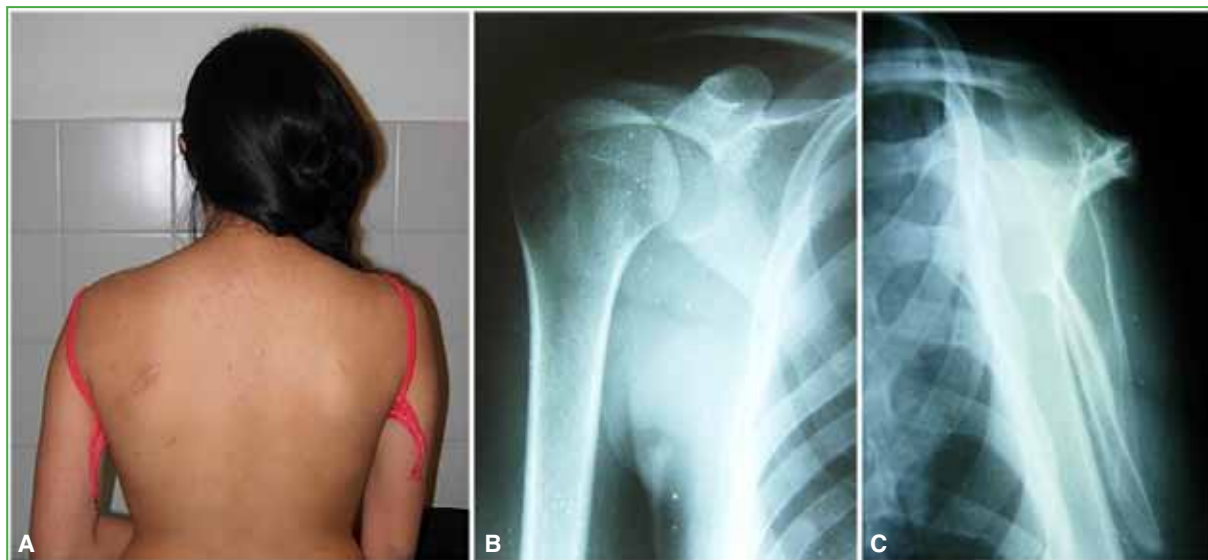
A. Dorsal view of the patient 2 years after surgery. Note the incision in the left scapular region. B. Follow-up shoulder radiograph, anteroposterior view. C. Follow-up shoulder radiograph, lateral view.
